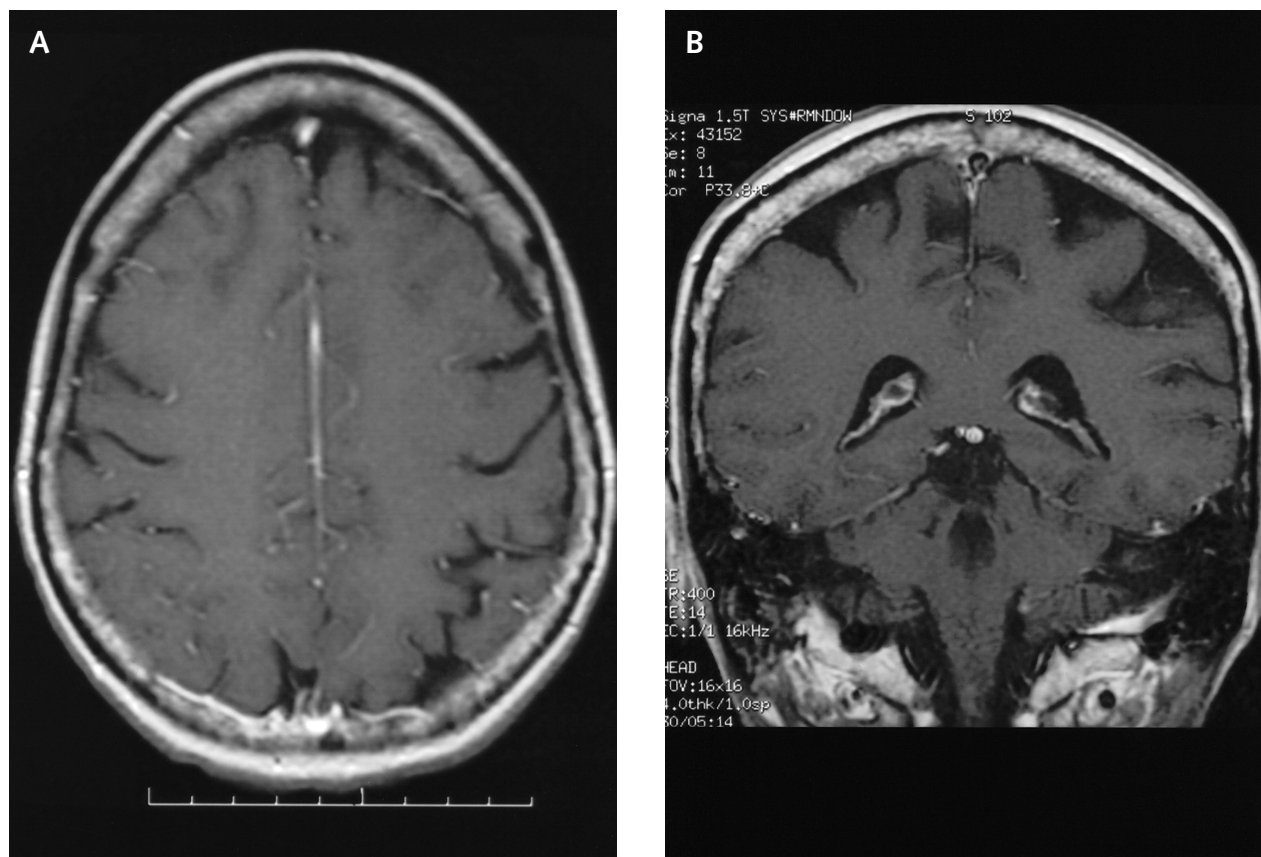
Patient 1—MRI brain scan 11 days post-ictus. Axial (A) and coronal (B) T1-weighted images of the brain following intravenous gadolinium administration; anatomically matched to Figs. 1A and 1B. Near-complete resolution of abnormal cortical enhancement.
